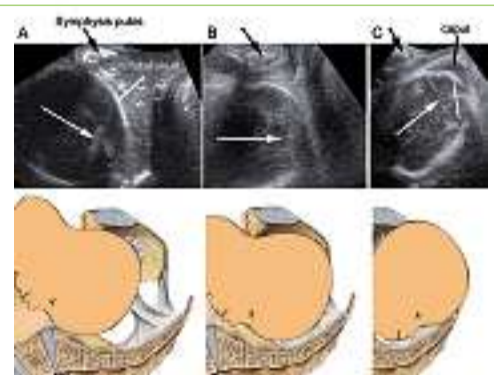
A sequence of sonographic images obtained with infrapubic translabial ultrasound in labor. The main anatomic landmarks of the fetal skull and symphysis pubis allow personnel to assess the progression at a glance. A was obtained during the first stage and demonstrates that the head is in the superior part of the pelvis. B was obtained during the second stage. Clinically, the fetal head had reached 1 cm below the ischiatic spines. C was obtained at the very end of the second stage, when clinically, the head was 4 cm below the ischiatic spines. Moulding of the fetal head and a considerable caput can be seen. The fetus was delivered 8 minutes after the scan was obtained. Note the direction of the fetus with regard to the symphysis in each panel (white arrows)
